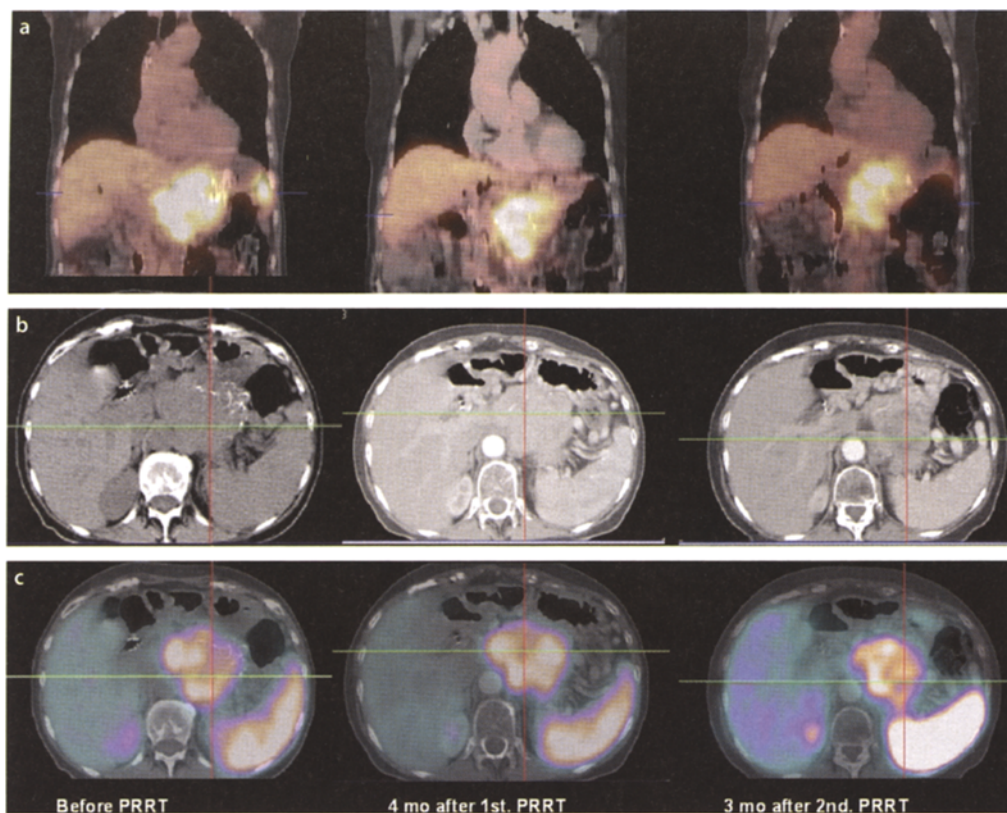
Large, inoperable neuroendocrine carcinoma of the pancreatic tail with infiltration of the stomach. Ga-68 DOTA-NOC receptor PET/CT (a coronal PET slices, b transversal CT slices, and c fused images before intra-arterial PRRT using Y-90 DOTA-TATE, 4 months after the first treatment, and 3 months after the second intra-arterial therapy) showing high but heterogeneous SMS-receptor expression. Before treatment, the 66-year-old patient needed multiple blood transfusions despite intense conventional treatment, including chemotherapy and Sandostatin. After the second PRRT, the bleeding stopped completely
